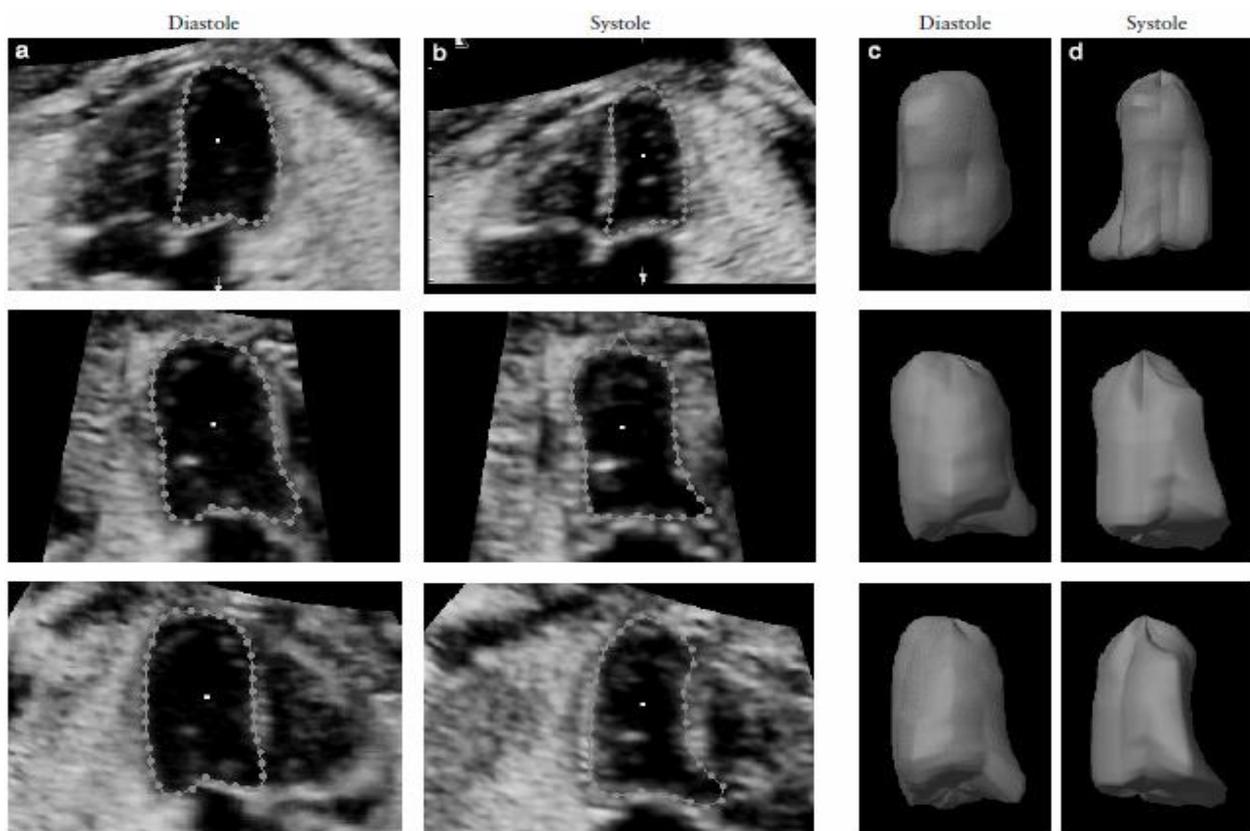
Three-dimensional ultrasound images of three different sections of the left ventricle in diastole (a) and systole (b) and the cardiac volumes derived from them using VOCAL (Virtual Organ Computer-aided Analysis) (c and d, respectively). Figure from Molina et al. (54).
